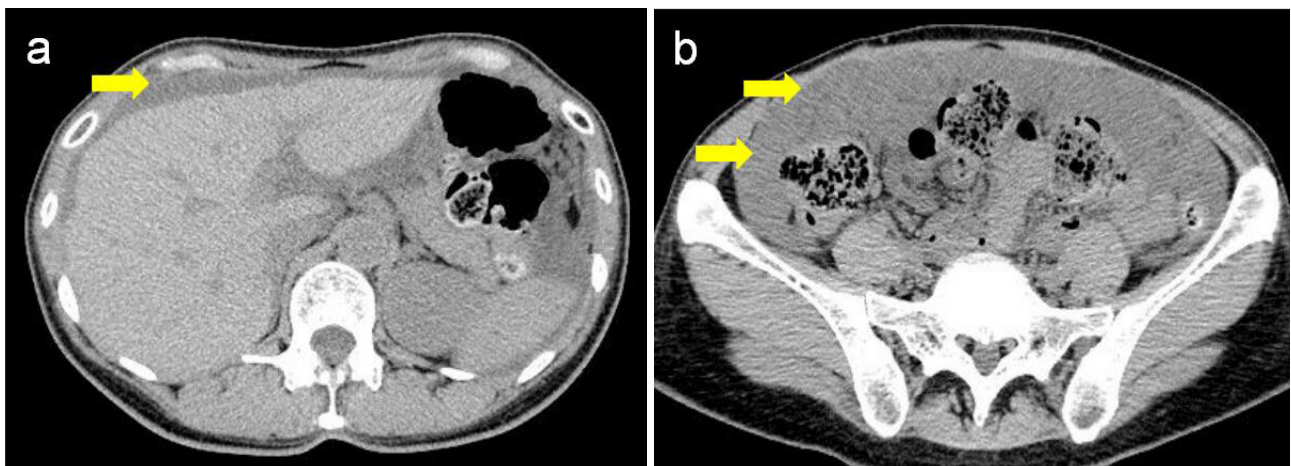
Abdominal CT scan showed ascites (yellow arrows) around the liver (a) and revealed ascites (yellow arrows) in the pelvic cavity (b) 31 months post appendectomy.
